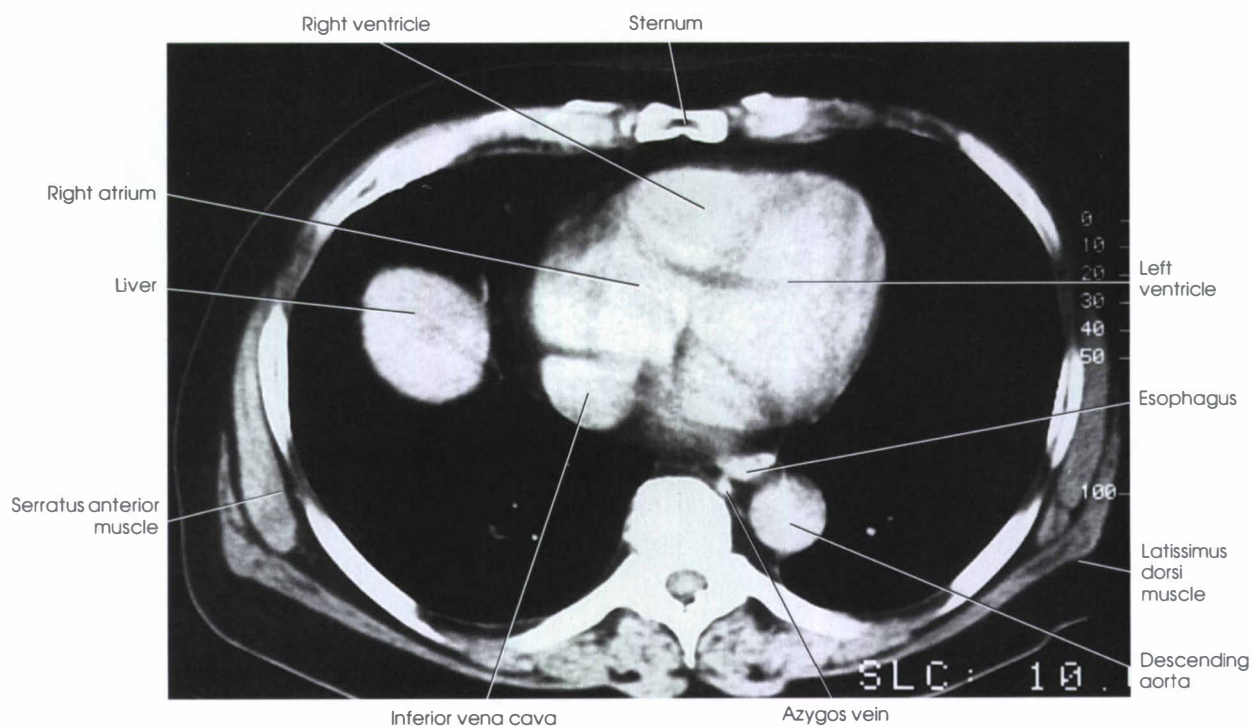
CT image corresponding to Fig. 27-23.
